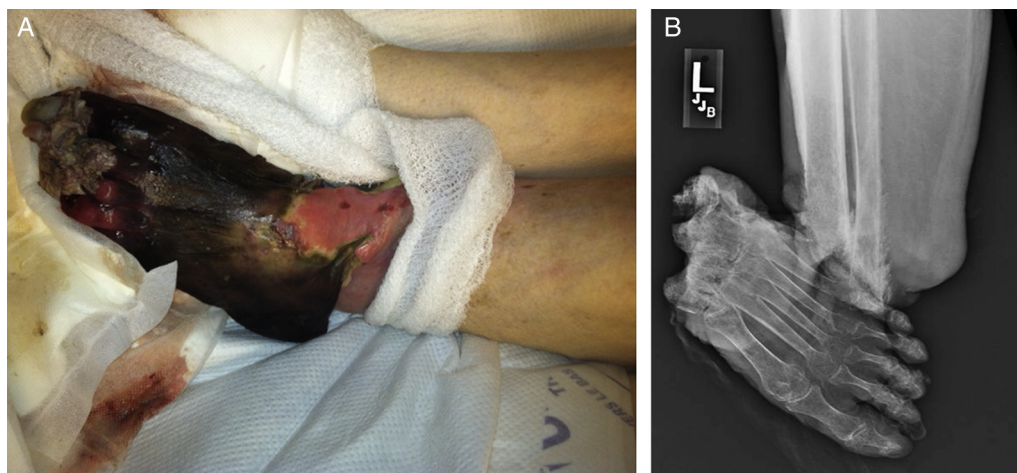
(A) Clinical photograph of a patient with a chronic wound that developed into wet gangrene requiring an above-the-knee amputation. The procalcitonin value for this patient was 0.81 ng/mL. This patient had a procalcitonin level less than the median threshold for a foot-sparing amputation; however, the patient clearly required a more proximal amputation, indicating the importance of clinical judgment. (B) Corresponding plain film radiograph of this patient.
